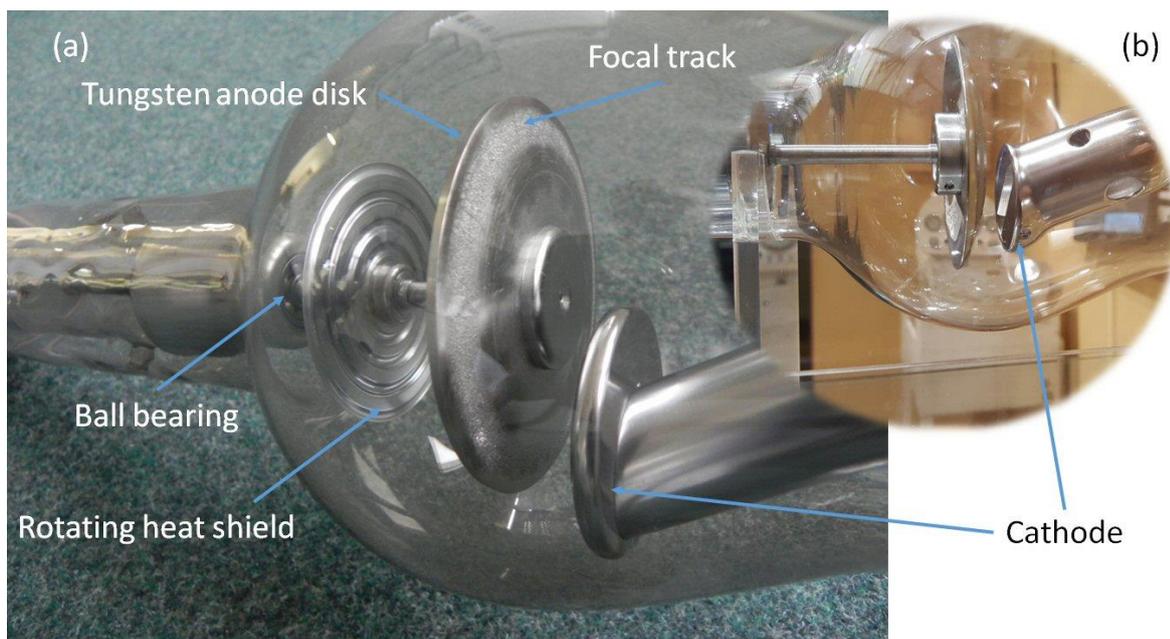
(a) Rotating anode system of a Siemens PantixTM tube, equipped with an all-tungsten high temperature anode disk and produced from 1933 by Siemens-Reiniger-Werke AG, Rudolstadt, Germany. While the RotalixTM tube primarily stored enthalpy at moderate temperatures in the finned copper / tungsten anode and radiated heat from a large surface area, the PantixTM design aimed at employing the Stefan-Boltzmann (T^4) law to achieve high heat radiation from a hot disk. (b) Earlier version without a heat shield at the rotating anode. (Picture (a) taken in the Siemens X-ray tube museum Rudolstadt, Germany, (b) taken at the Medizinhistorisches Museum Hamburg, UKE, Germany.)
